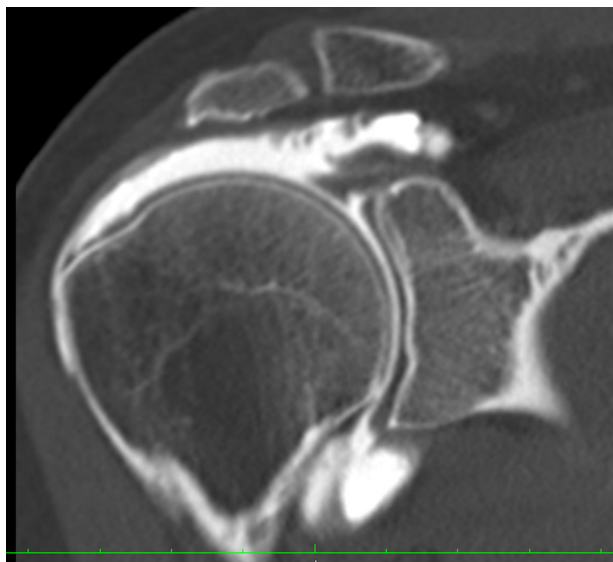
CT arthrogram. Coronal view. Grade-3 supraspinatus tendon tear with glenoid retraction.
